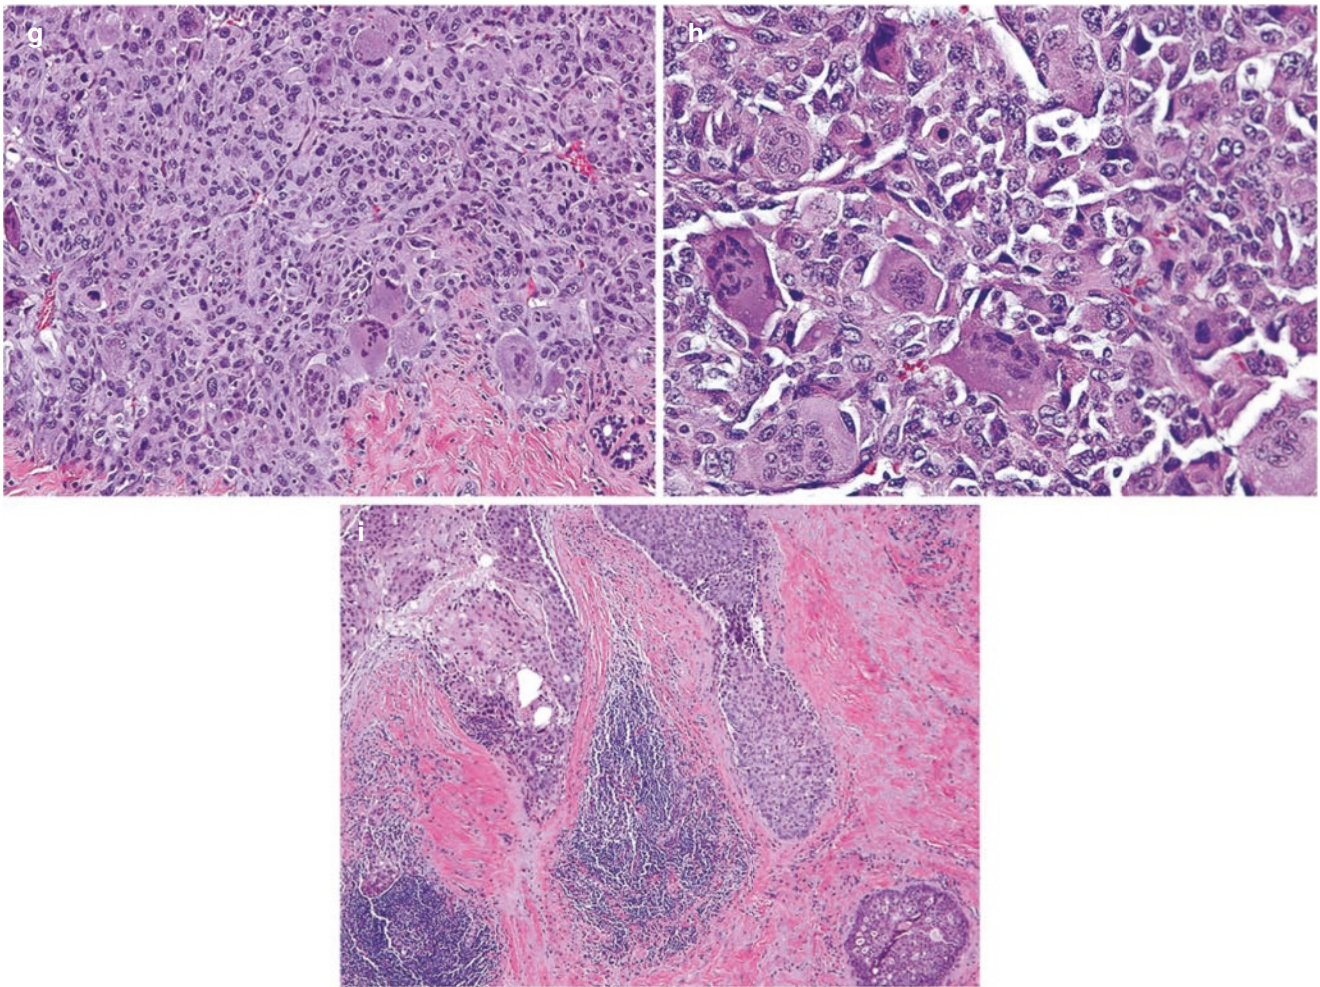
Metaplastic/sarcomatoid carcinoma with osteoclast-like giant cells. (a) A 52-year-old women presented with a large palpable mass in her right breast. Diagnostic mammogram revealed a 4 cm lobulated, partially circumscribed, partially obscured mass, which was further confirmed by (b) sonogram. (c) Core needle biopsy was performed and showed a cellular high-grade neoplasm with mixed spindle, pleomorphic cells and osteoclast-like giant cells. The differential diagnosis includes metaplastic/sarcomatoid carcinoma versus sarcoma. (d, e)
